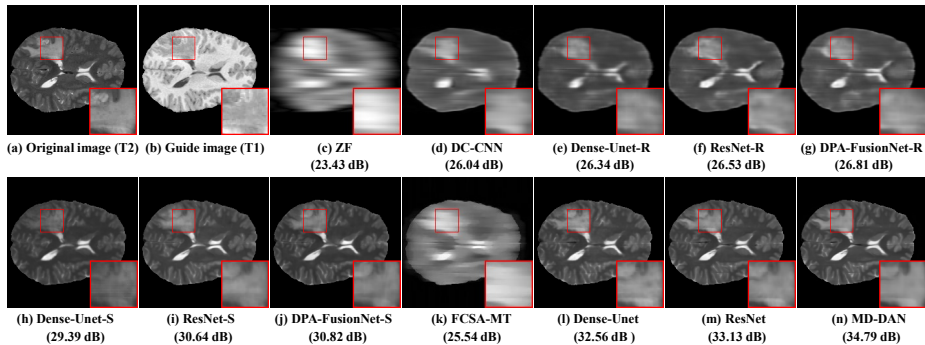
Results for a brain MR image using 1/32 1D Cartesian sampling.
